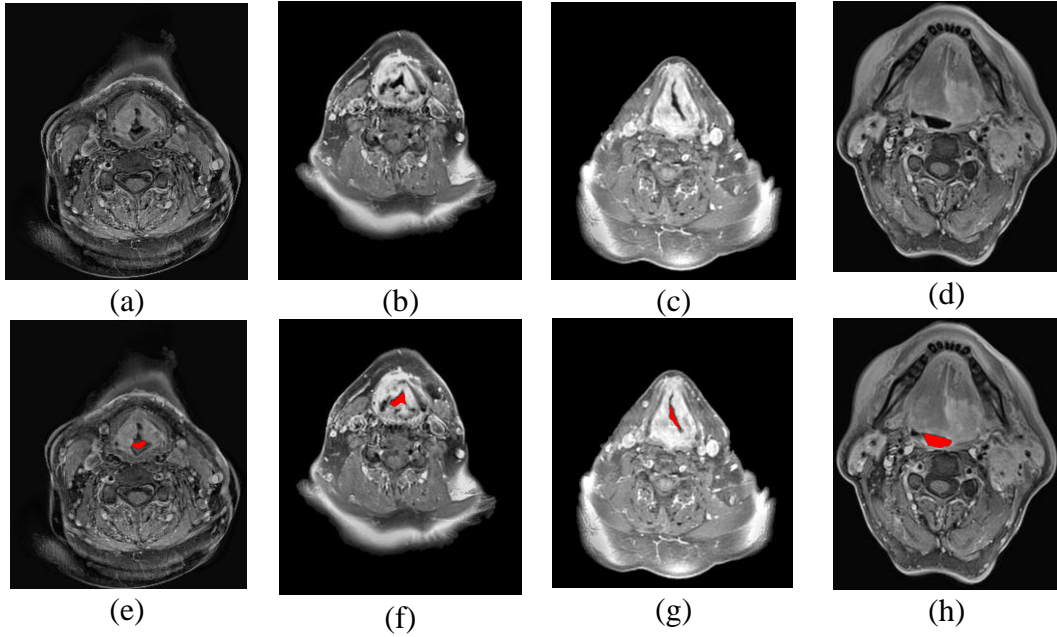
Throat detection examples. (a-d) Input MRI slices (MR09112012, MR19062012, MR27082012 MR09082010) (e-h) Input MRI slices with detected throats marked with red.
